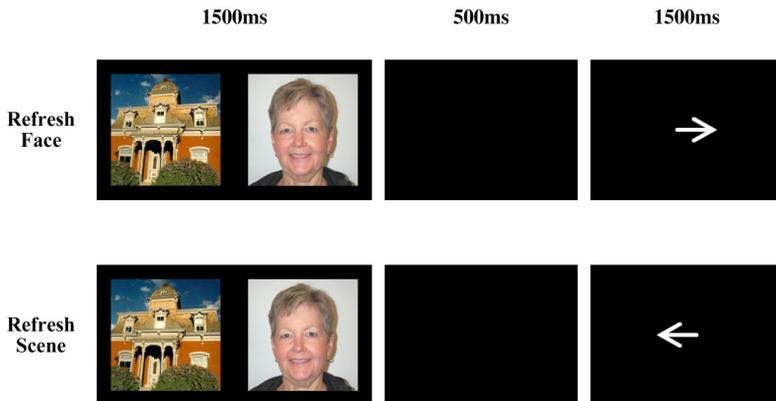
Structure of a typical refresh task used in functional MRI experiments.
